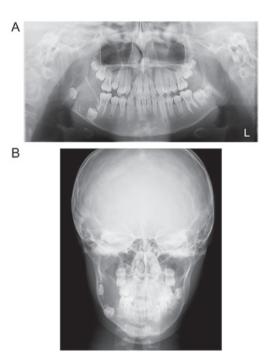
Initial conventional radiographs. (A) Panoramic and (B) posteroanterior radiographs revealing the presence of a well-defined, unilocular, radiolucent lesion with a smooth margin associated with impacted lower right second and third molars. L. left side.
